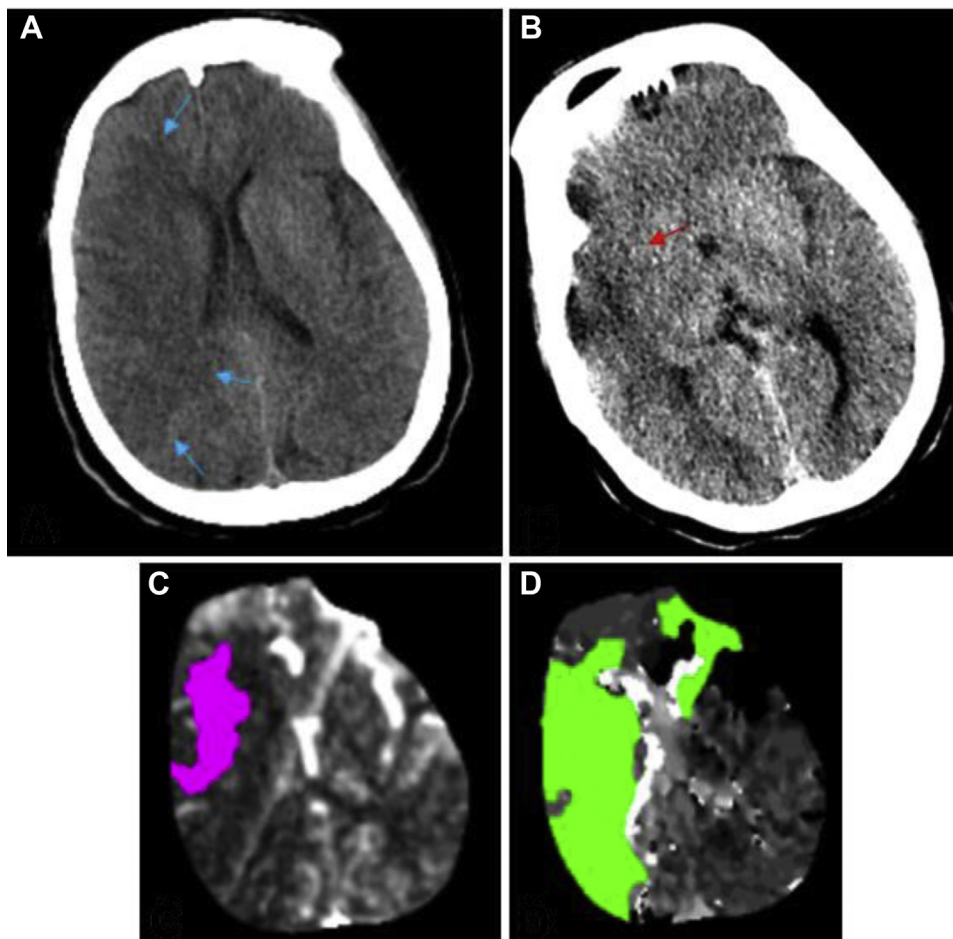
Computed tomography angiogram with perfusion imaging demonstrating right middle cerebral artery (MCA) territory stroke with large penumbra. A and B, Computed tomography scan of the brain showing loss of gray–white matter differentiation along the right MCA territory, including areas of frontal, parietal, and temporal lobes (*blue arrows*) and insular cortex (*red arrow*), suggestive of right MCA ischemic stroke. C and D, Perfusion map displaying cerebral blood flow $<30\%$ (*pink*) and time-to-peak concentration >6 seconds (*green*), representing predicted core infarct and potential penumbra, respectively.
